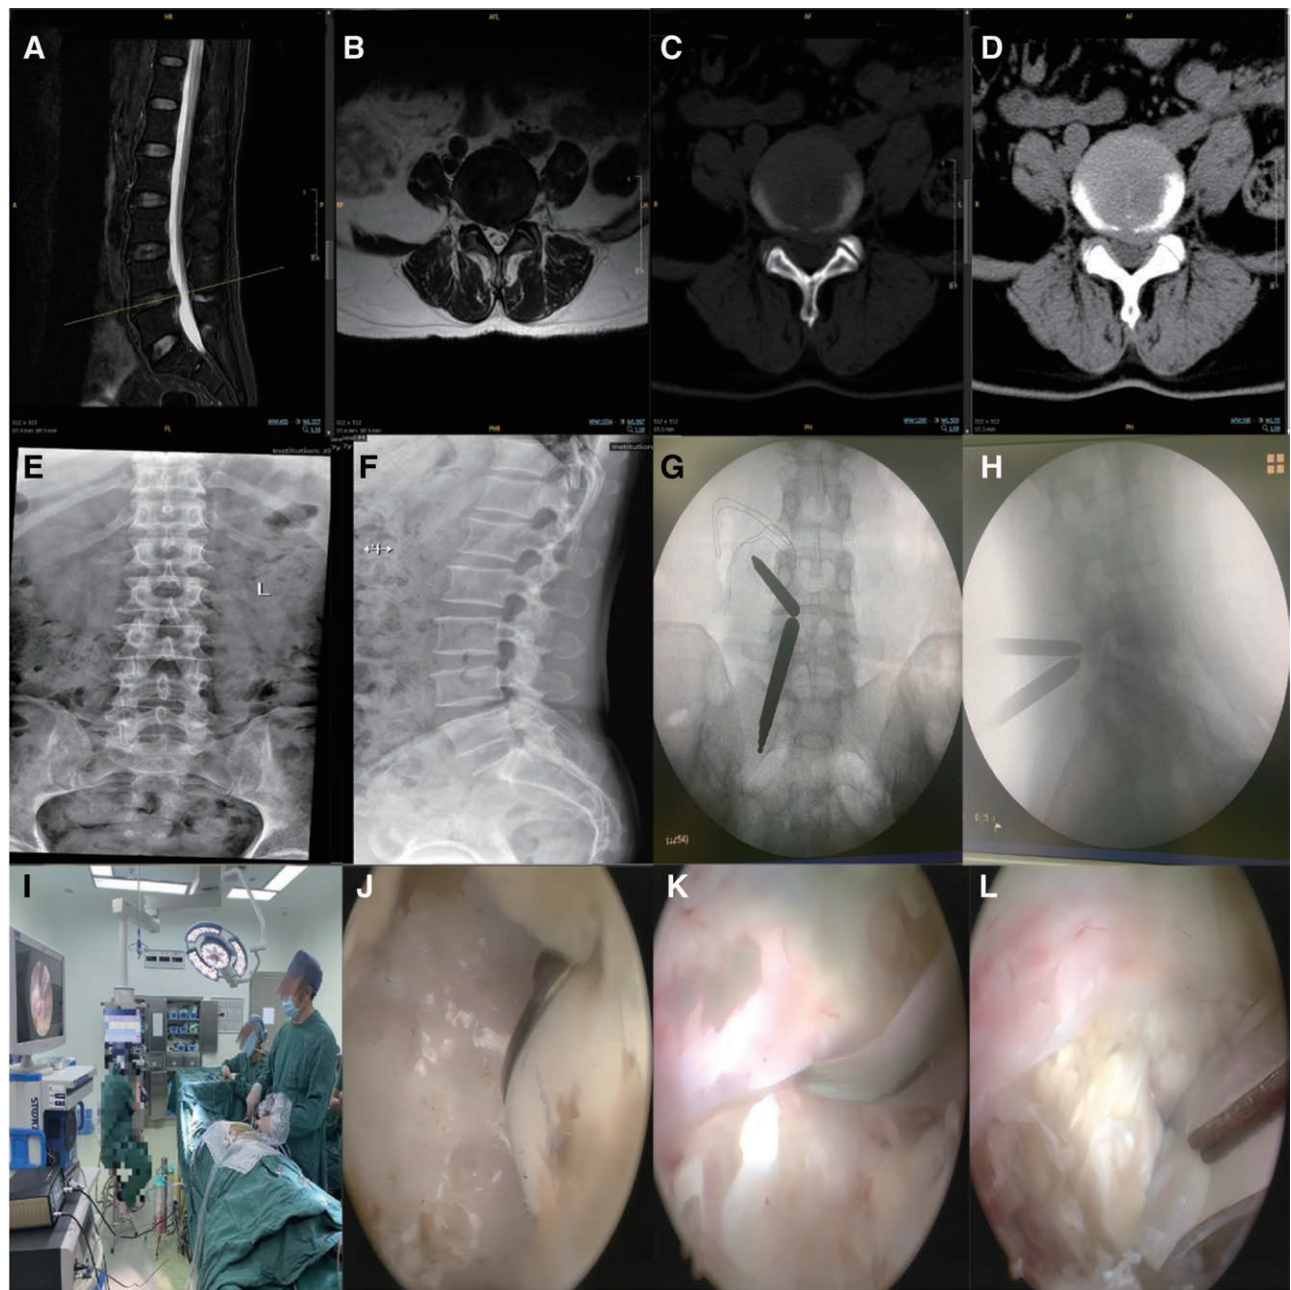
Lumbar disc herniation at the L4/5 level. Intraoperative imaging of a 28-year-old female with back and left leg pain during UBE. T2-weighted parasagittal MR and CT revealing down migrated disc herniation at L4/5 level (A through D). Frontal and lateral X-ray images reveals physiological anterior curvature of the lumbar spine (E and F). Two operation channels located on the targeted intervertebral lacunae by X-ray images (G and H). The surgeon was reducing compression (I). Exposing the vertebral plate, shake off part of the medial aspect of the lower articular process, and expose the nerve root and protruding intervertebral disc fully, and remove it completely (J through L). CT = computed tomography, MR = magnetic resonance, UBE = unilateral biportal endoscopic discectomy.
